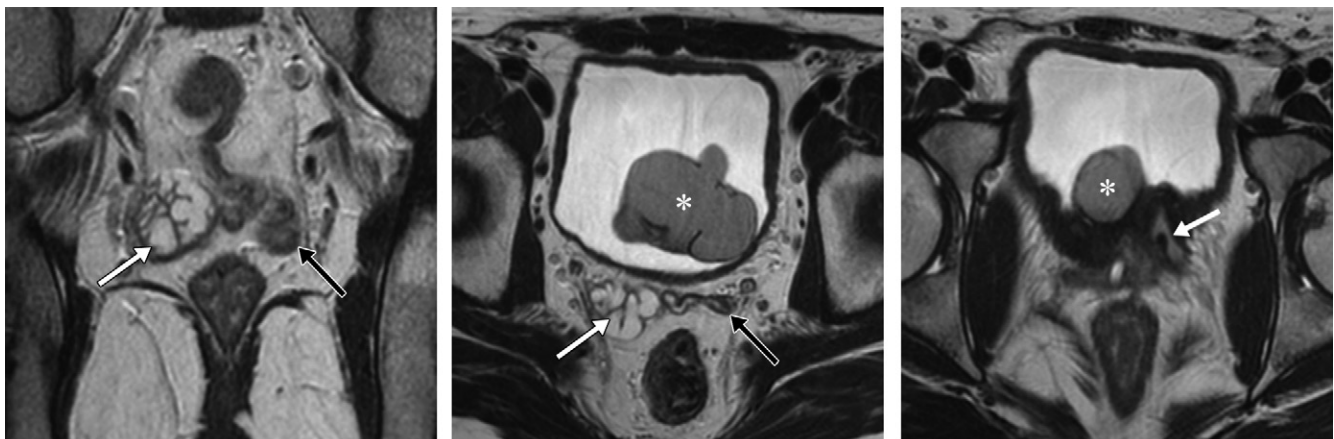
Images from coronal (a) and (b, c) axial fast spin-echo T2-weighted MRI of the pelvis, with b being superior to c, show the atrophied left seminal vesicle (black arrow) and prominent right seminal vesicle (white arrow in a and b). Ectopic insertion of the left ureter is seen (arrow in c) here and joins the lobulated intravesicular cecoureterocele (*) in Figure 2c.
